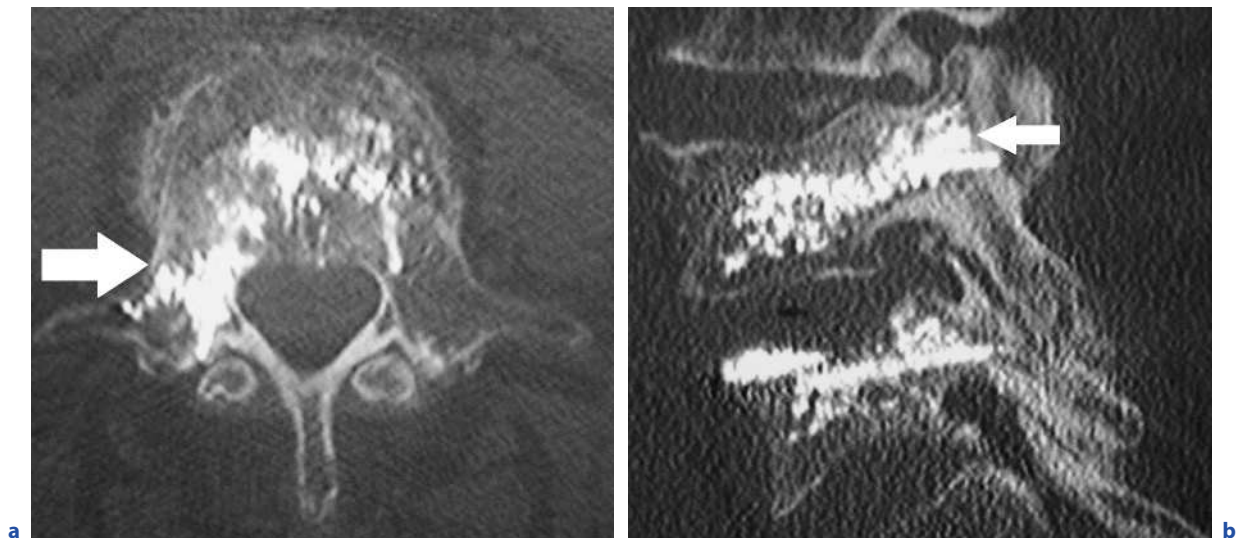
Axial (a) and sagittal (b) CT images show a lytic lesion in the L2 vertebra. Previous CT biopsy tract (b, arrow) is shown which confirmed the lesion to be secondary to myeloma. c Lateral fluoroscopy image at the end of the vertebroplasty shows the cement fill
